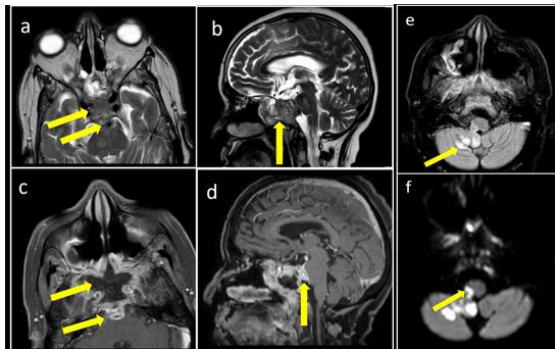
(a-d) Axial and sagittal T2W (a,b), axial and sagittal T1 post contrast (c,d) images demonstrate retroclival soft tissue indenting on the pons and encasing the basilar artery. (e,f) Follow up imaging after 4 days: Axial FLAIR (e) and DWI (f) images show development of infarcts in the cerebellum and medulla.
